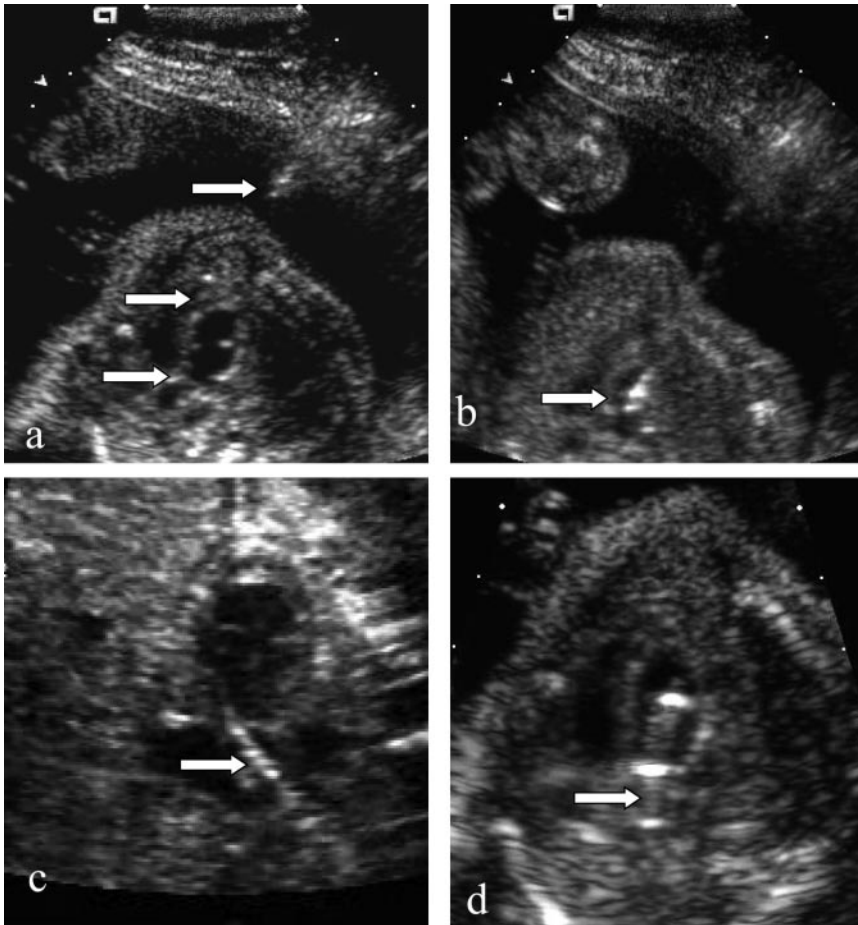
Ultrasound images of technically successful percutaneous in utero aortic valvuloplasty. a, LV before intervention. Four-chamber view demonstrating echogenic LV, apex-forming RV, and alignment of needle (arrow), LV apex (arrow), aortic valve, and ascending aorta (arrow). b, Cannula in LV. After LV puncture with cannula, LV appears smaller. Cannula can be seen as echo-bright line in LV, with its tip directed at aortic valve (arrow). c, Guidewire across aortic valve in ascending aorta (arrow). d, Balloon across aortic valve. Correct position of balloon across aortic valve is confirmed by external measurements of catheter and by ultrasound imaging. Balloon inflation appears as movement of bright reflection along line of LV outflow track and across level of valve (arrow).
